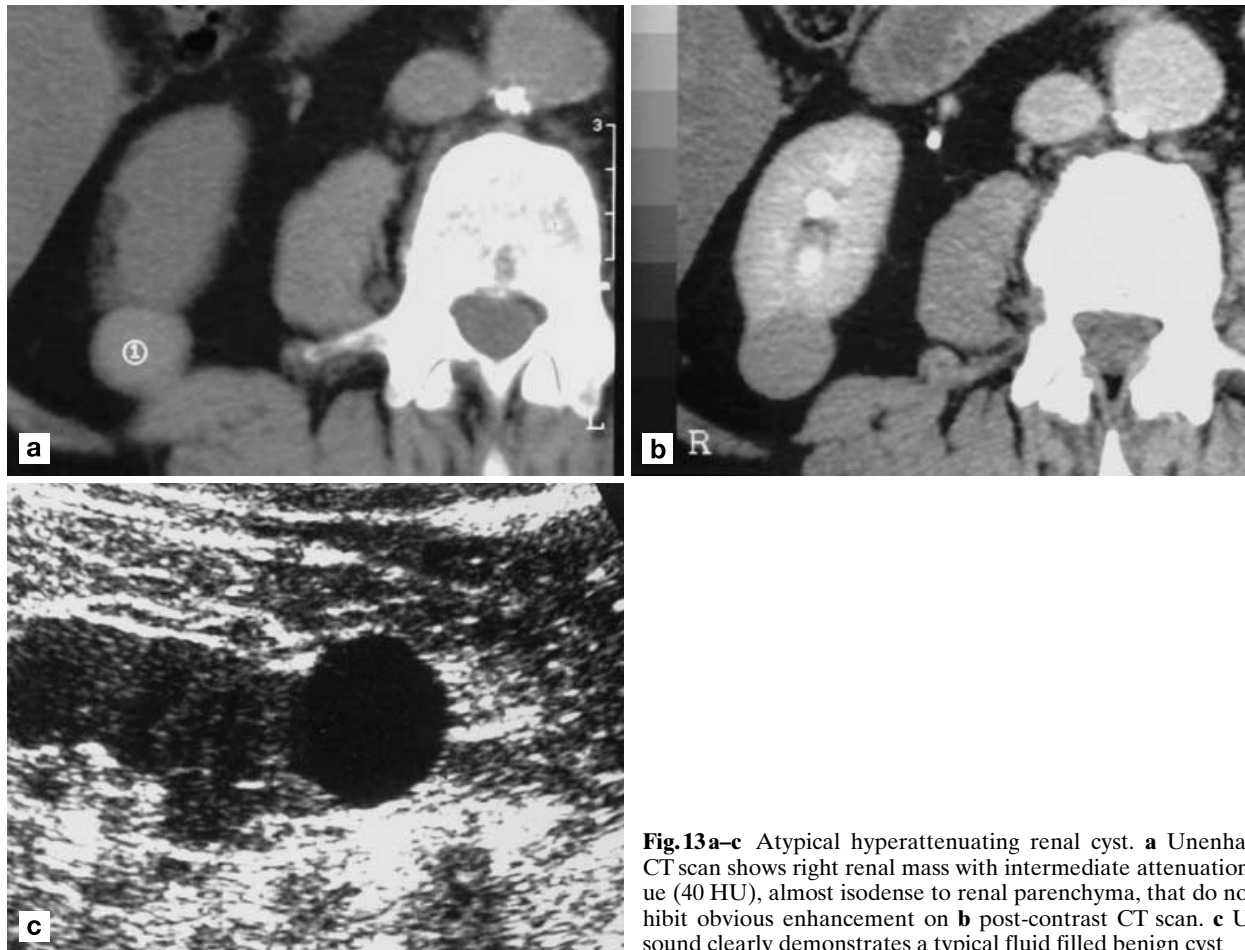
Atypical hyperattenuating renal cyst. a Unenhanced CT scan shows right renal mass with intermediate attenuation value (40 HU), almost isodense to renal parenchyma, that do not exhibit obvious enhancement on b post-contrast CT scan. c Ultrasound clearly demonstrates a typical fluid filled benign cyst
